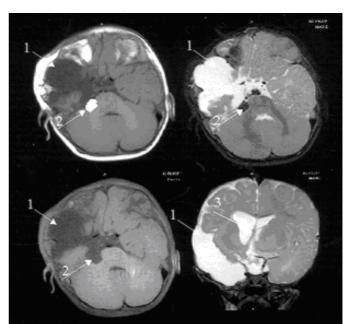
Magnetic Resonance Image of the head. On the upper left a T1weighted image, on the upper right a T2-weigheted image, on the lower left a T1weighetd image with fat saturation. All the three axial slices are on the same level. On the lower right a coronal T2-weighetd slice is shown, through the temporal lobe. Note the arachnoid cyst on the temporal fossa, T1 hypointense and T2 hyperintense (arrows 1). The lipoma is seen next to the pons (arrows 2), bright on T1-w, black on T2-w and excluded on the fat saturation image. The coronal slice shows better the relationship between the arachnoid cyst and temporal lobe atrophy with ventricle enlargement (arrows 3).
